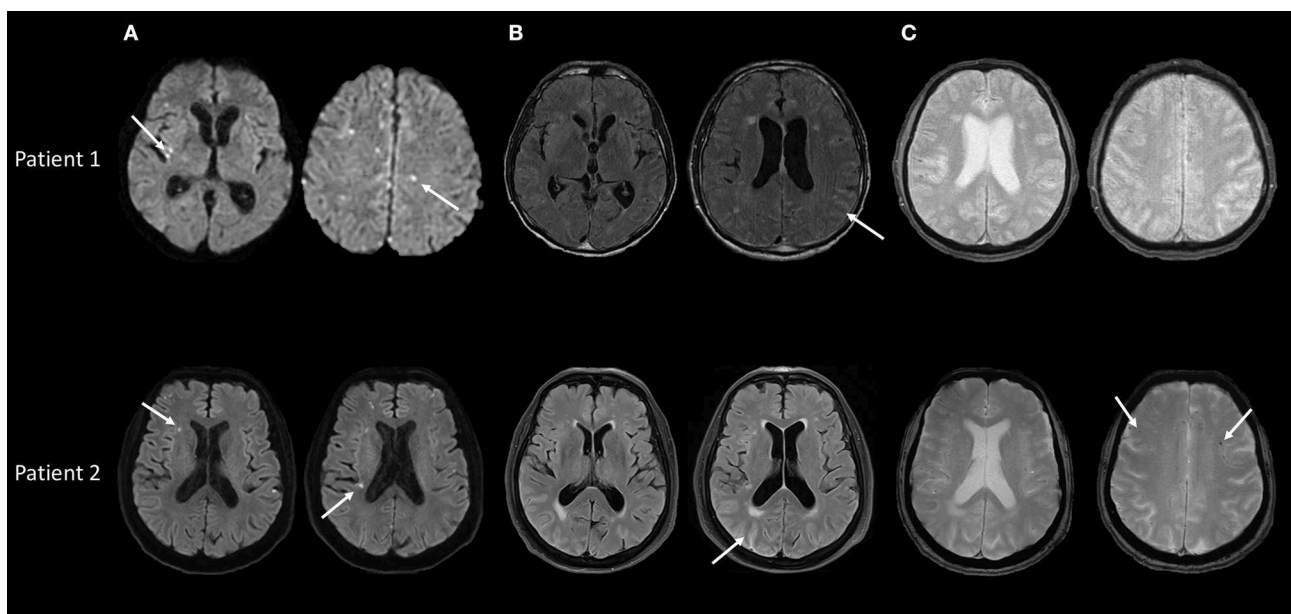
Baseline brain MRI in patients 1 and 2, performed during the first month of the disease. (A) Diffusion weighted sequences showing multiple deep and cortical acute microinfarcts in both patients (arrows). (B) FLAIR sequences showing no or minimal brain parenchymal lesions but high intensity signal in cortical sulci in patients 1 and 2 (arrows). (C) T2* sequences showing doubtful sulcal hypointensities in patient 1 and 5 microbleeds in patient 2 (arrows).
